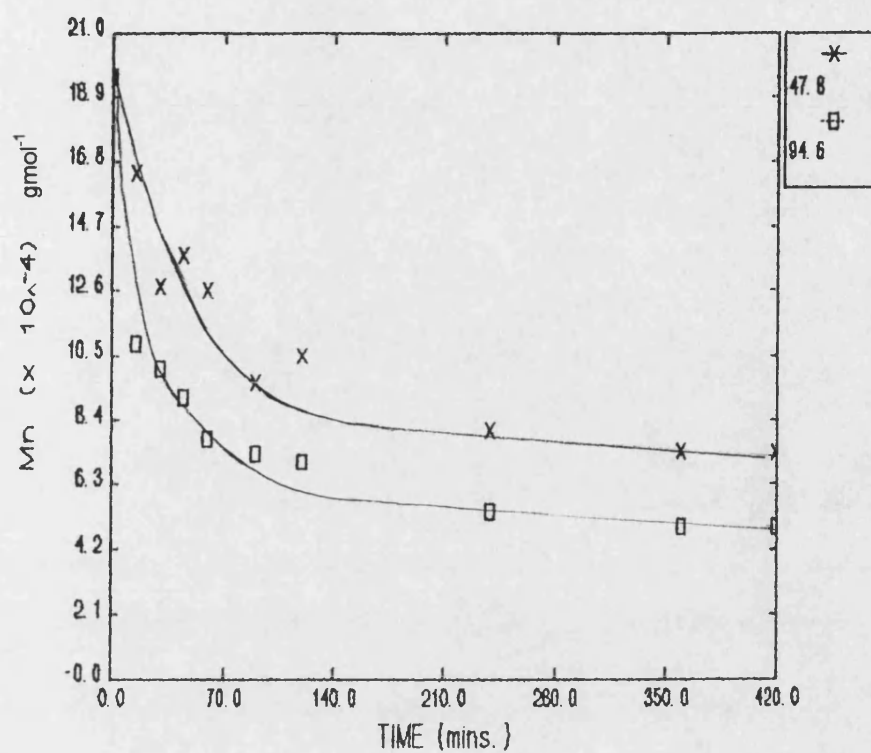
Effect of varying ultrasonic intensity upon  $M_n$  for a 0.5 % (w/v) solution
